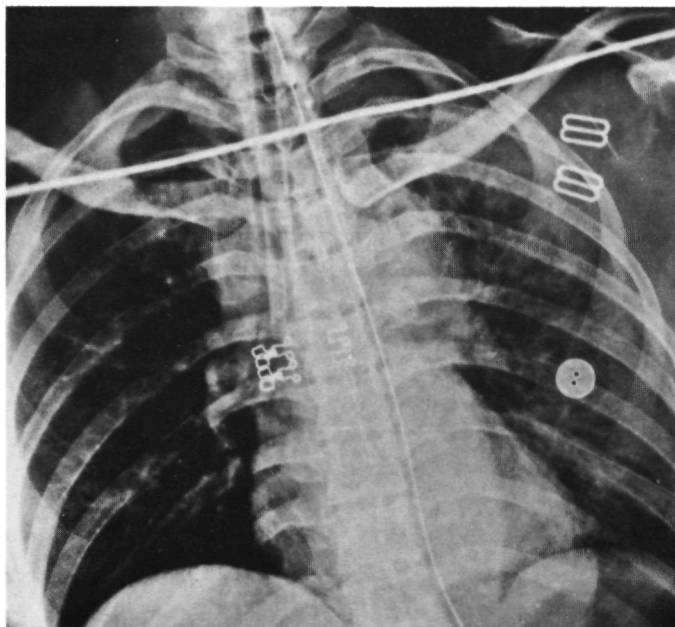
6 Female, 30 years, car-passenger, TAR. Death on the 6th postoperative day due to sepsis. Chest X-ray: tracheal displacement to the right and normal position of the nasogastric tube. Widening of the mediastinal shadow (10 cm). Unsharp aortic outline. Widened paratracheal stripe.
